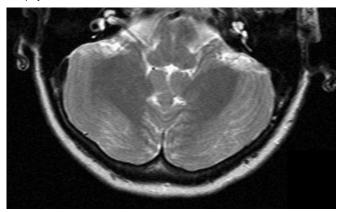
Normal MRI Brain T2 sequence at the same level, for reference from radiology assistant.
